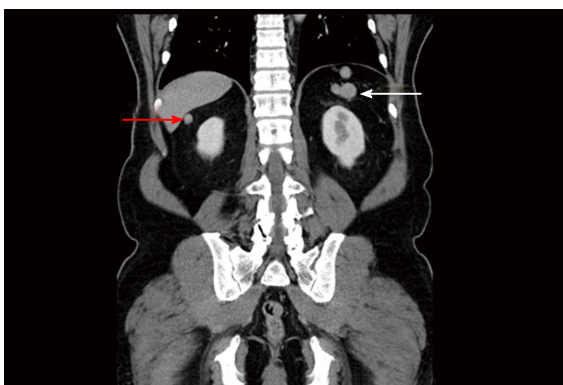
Coronal computed tomography image of the pelvis. White arrow pointing to nodular soft tissue mass in left upper quadrant, where discrete spleen was not visualised; red arrow pointing to soft tissue mass beneath liver.
